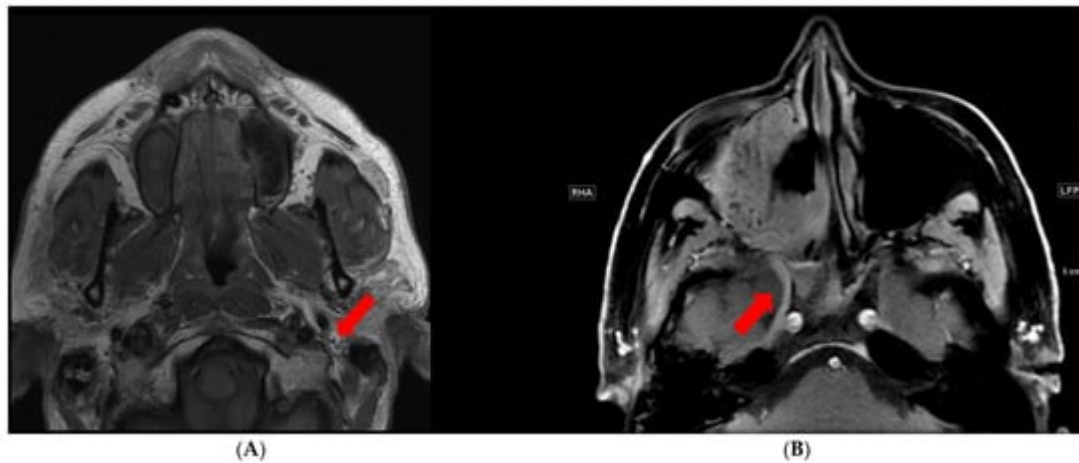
PNTS as seen on MRI. (A) Normal T1 hyperintense triangular fat around the facial nerve (arrow). (B) Postcontrast fat suppressed T1 image shows abnormally enhancing right V2 (arrow) and the pterygopalatine fossa.
